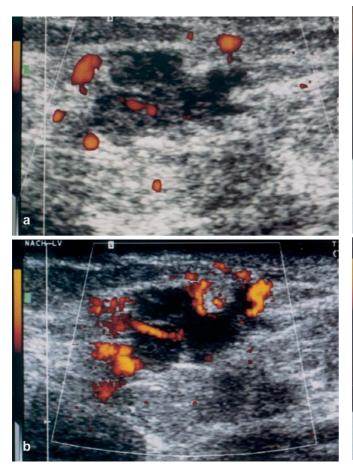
a Plain power Doppler US shows only three paracentral intratumoral color dots representing arterial vessels. The vascular structure of this ductal invasive carcinoma cannot be analyzed sufficiently. The peritumoral vessels seem to be emphasized. b After application of the contrast agent, the rim-penetrating, tortuous, irregular centripetal vessels are visible as a sign of tumor neoangiogenesis. The peritumoral vascularity is lower than the intratumoral vascularity
